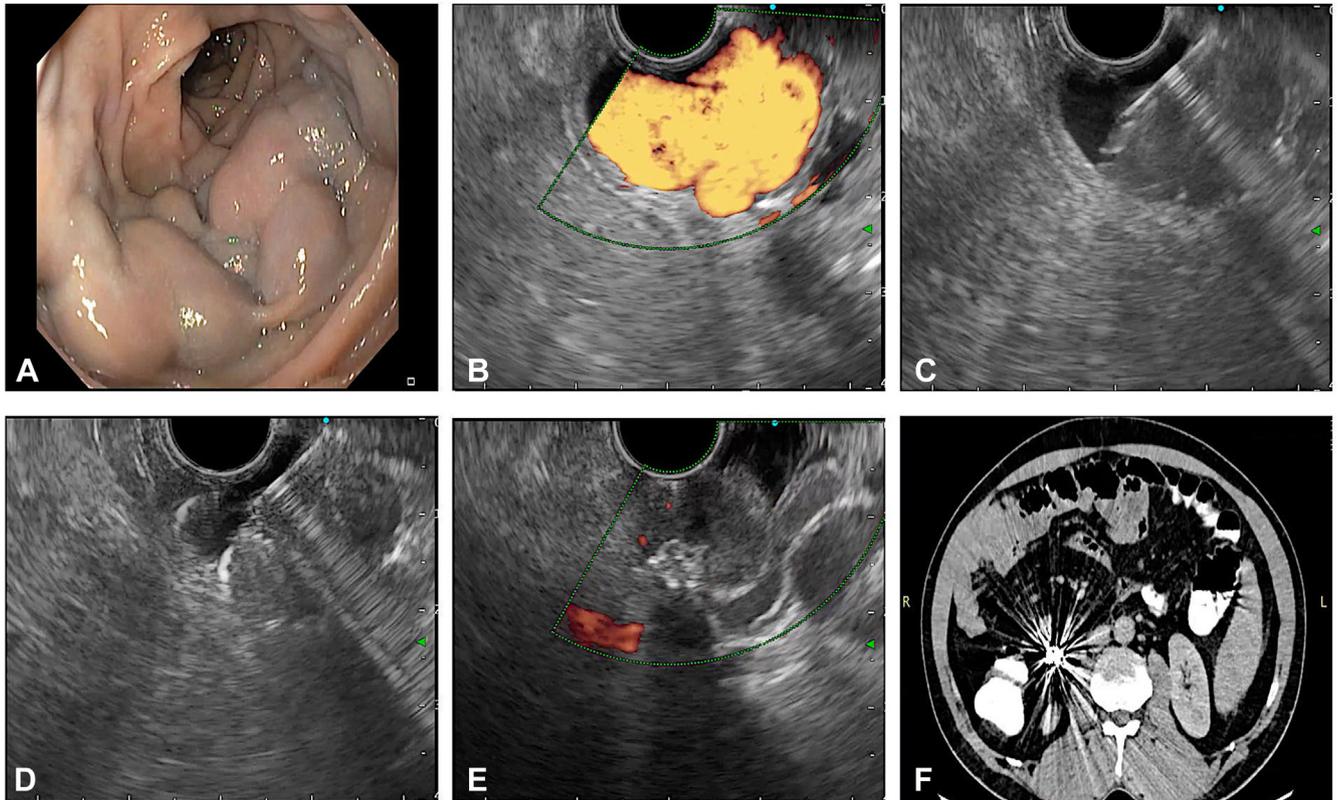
EUS-guided embolization of ectopic duodenal varices by direct varix puncture and embolization method. A, Endoscopic view of large varices (occupying more than one-third of circumference) in part 3 of the duodenum. B, EUS image showing strong Doppler flow within the large duodenal varix. C, Duodenal varix was punctured with a 19-gauge needle under EUS view. D, Coils were deployed into the varix with a 19-gauge needle. E, Complete thrombosis of the duodenal varix with absent Doppler flow, and coil–glue cast was seen on EUS. F, Follow-up contrast-enhanced CT scan of the abdomen showed complete obliteration of the varix with no flow in venous phase and coils in situ in part 3 of the duodenum.
